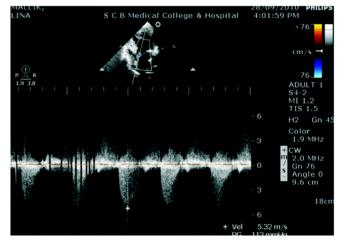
5 Apical 5 Chamber View. Continuos Doppler Across Aortic Valve Showing Gradient Of 113 Mm Hg
